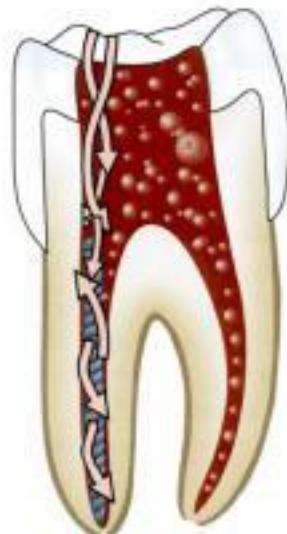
Ultrasonic activation of irrigating solution
